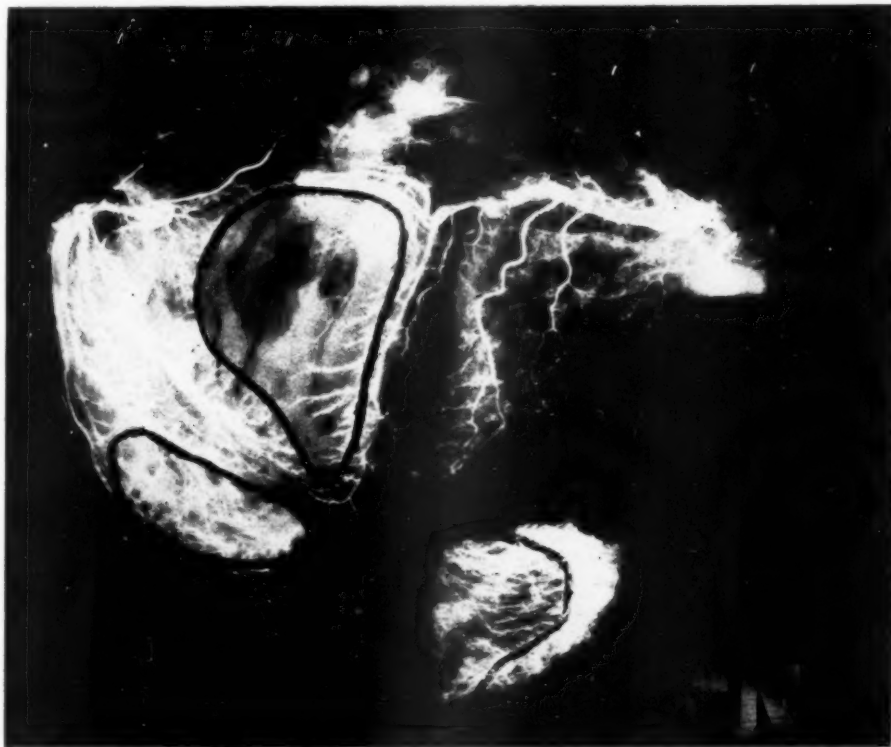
Roentgenogram of the injected heart of Case 19.
